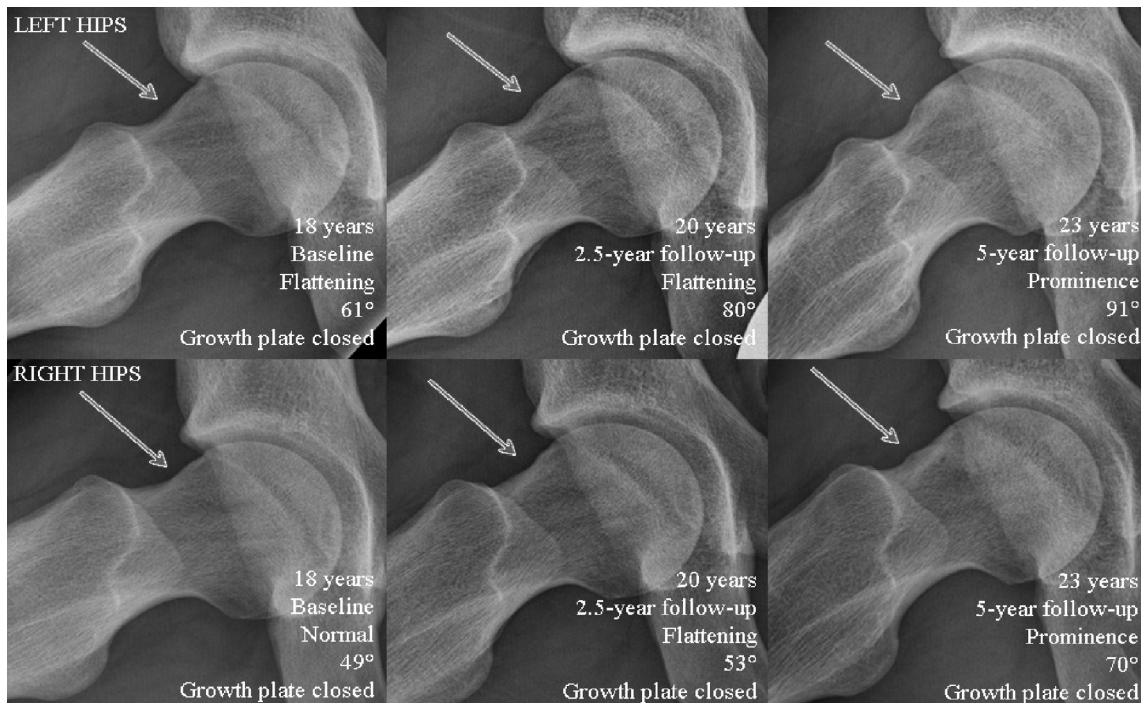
Cam morphology development based on alpha angle and visual score on frog-leg lateral radiographs of one person during follow-up. All presented hips have closed growth plates. Note: From baseline (normal) to 2.5-year follow-up (flattening) and from 2.5-year follow-up to 5-year follow-up (prominence), cam morphology development is observed. Cam morphology development based on alpha angle is noticed in the right hip from 2.5-year follow-up (53°) to 5-year follow-up (70°).
